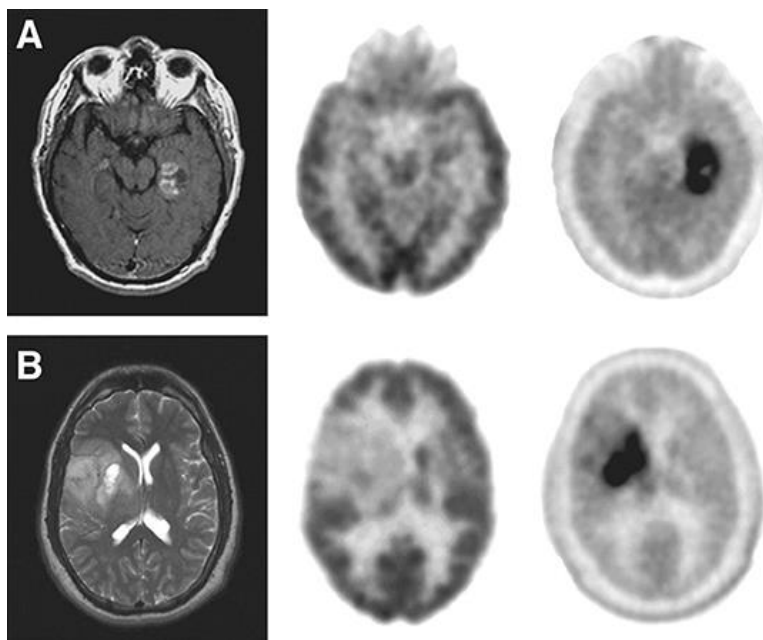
MRI of newly diagnosed tumors (left), ^{18}F -FDG PET (center), and ^{18}F -FDOPA PET (right). (A) Glioblastoma (B) Grade II oligodendrocyte glioma. This study was originally Chen et al. it was published in.
